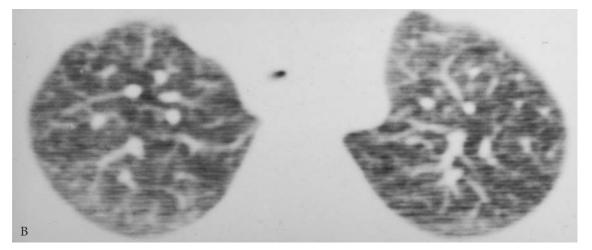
Post-traumatic tracheal stenosis. A, Computed tomography scan with intravenous contrast material demonstrates a narrowed, misshapen trachea surrounded by soft tissue density, consistent with fibrosis at the site of healed tracheal rupture. B, A lung window through the superior mediastinum reveals marked tracheal stenosis.
